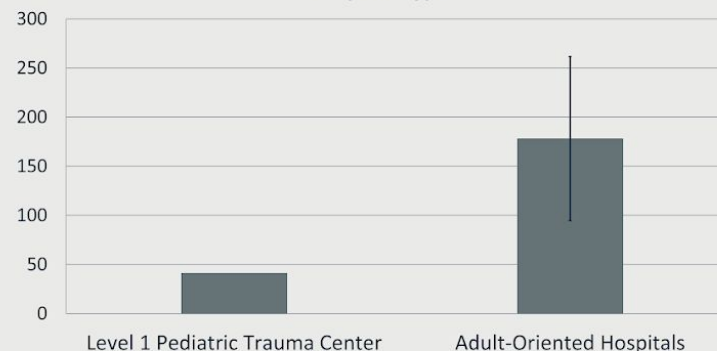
CT Scans Per Clinically Significant Injury by Hospital Type
